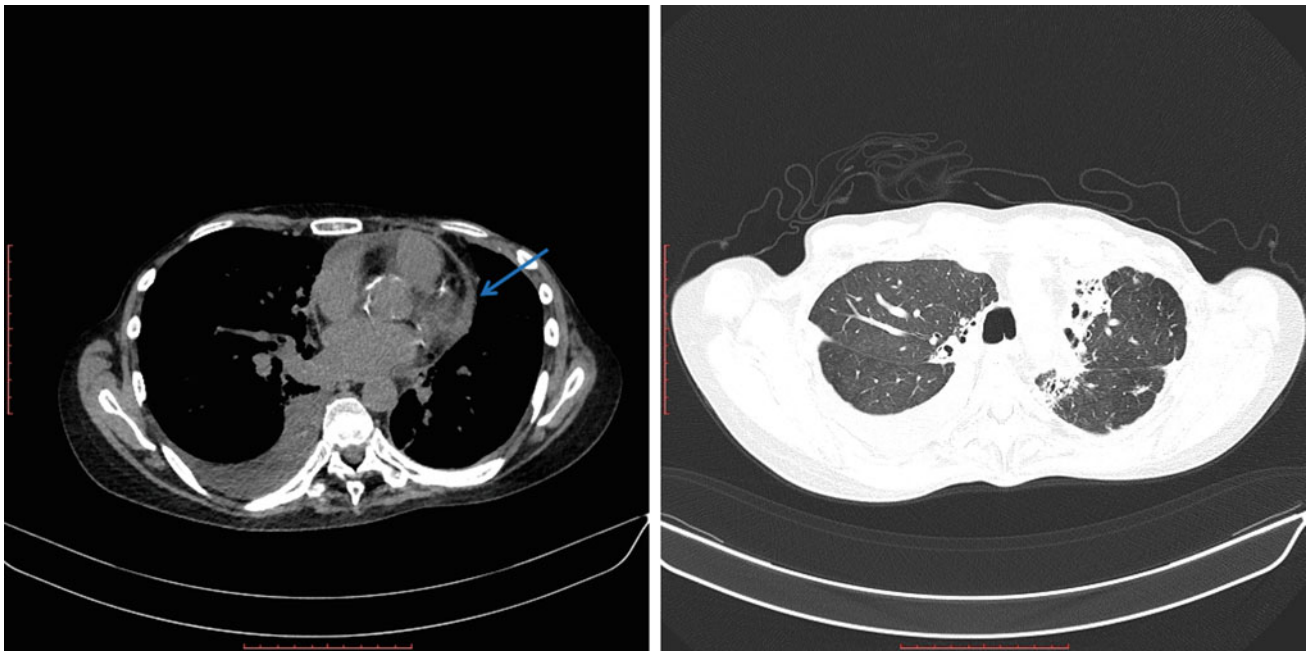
Lung CT scans (Nov 2018) demonstrating post-radiation fibrosis - fibroatelectasis in the paramediastinal parts of lungs, traction bronchiectasis in the upper and middle lobes, lost volume of the left
